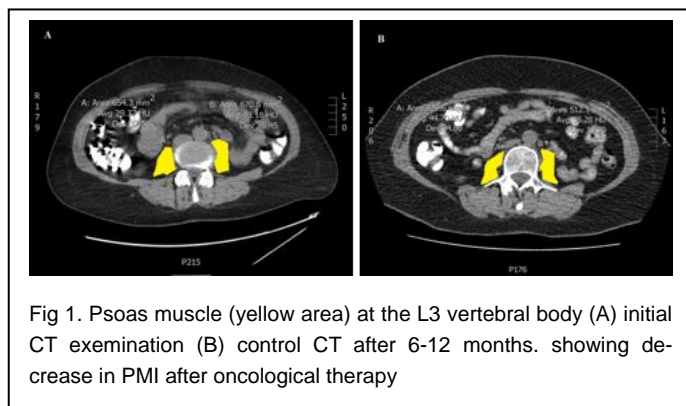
Psoas muscle (yellow area) at the L3 vertebral body (A) initial CT examination (B) control CT after 6-12 months. showing decrease in PMI after oncological therapy
